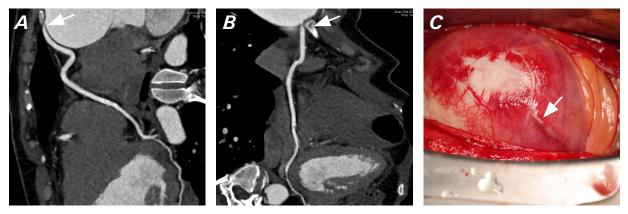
A) and B) Preoperative computed tomography coronary angiogram shows a proximal RCA stenosis. C) Operative findings show the stretched RCA on the dilated sinus.
